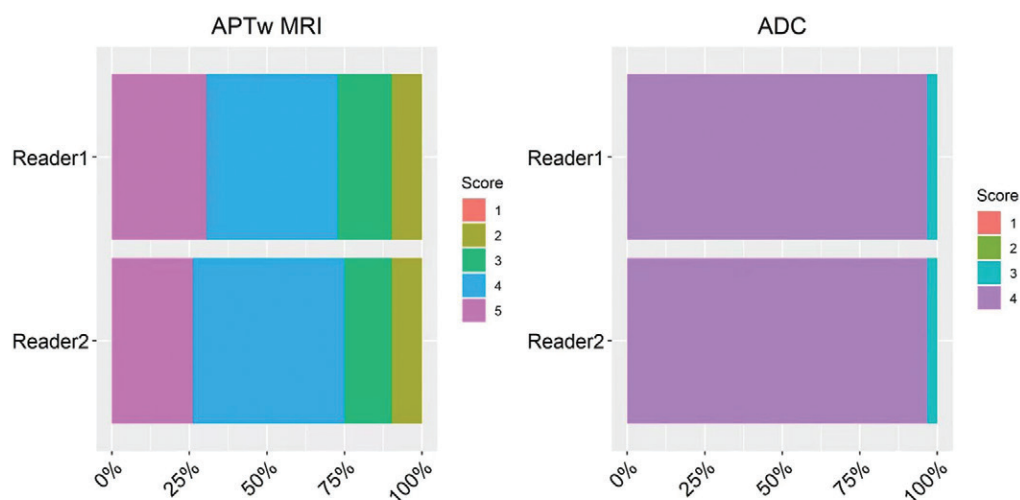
The image quality scores of the two readers for amide proton transfer-weighted (APTw) MRI and apparent diffusion coefficient (ADC) images.
